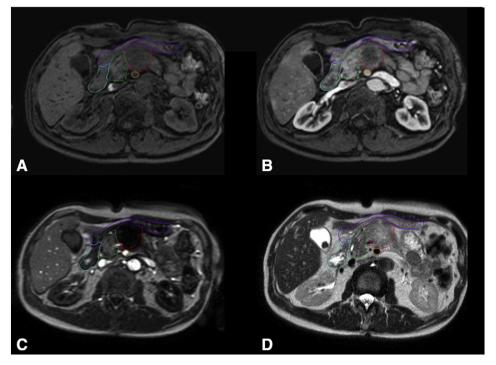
Contouring of an unresectable pancreatic tumor in the pancreatic body on pre contrast T1-weighted (A), arterial T1-weighted (B), T1-weighted (C), T2-weighted (D). Red: GVT, turquoise: duodenum, dark green: pancreatic head, purple: stomach. (Color version of figure is available online.)
